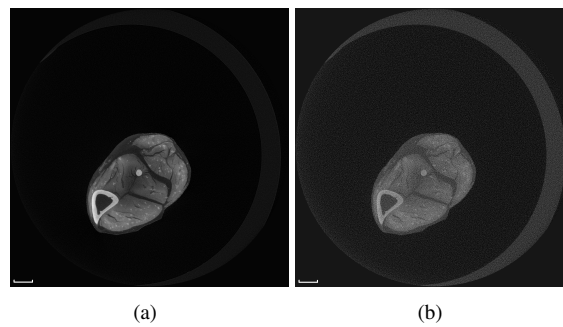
Reconstructed CT slice of the scans performed at 50 kV using 1 mm Al (a) and at 180 kV using 1 mm Cu (b). Scale bar = 1 mm.
